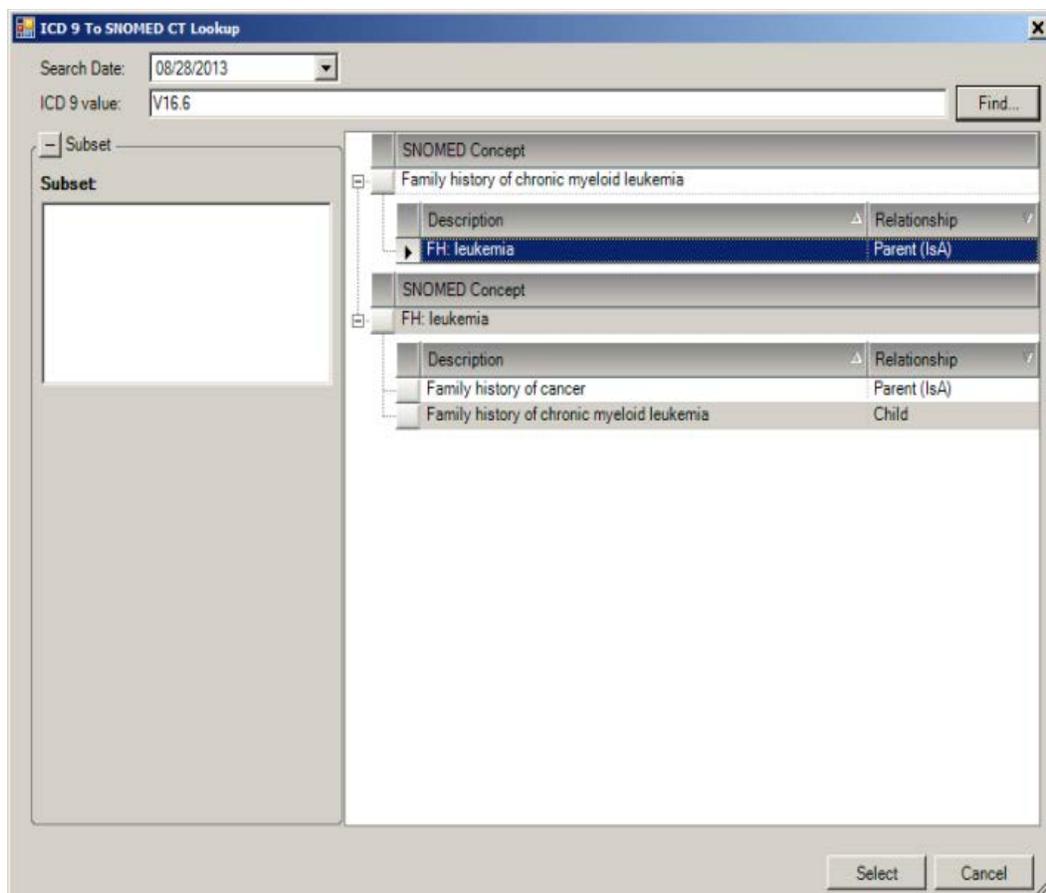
ICD 9 to SNOMED CT Lookup dialog
